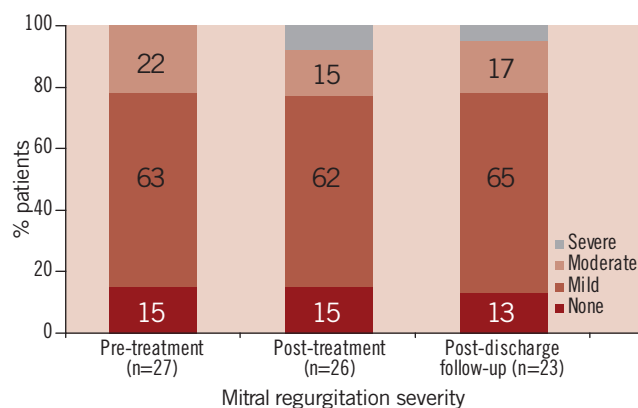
Severity of mitral regurgitation during serial echocardiographic evaluation (n=number of patient echocardiograms with sufficient information for assessment of mitral regurgitation).
